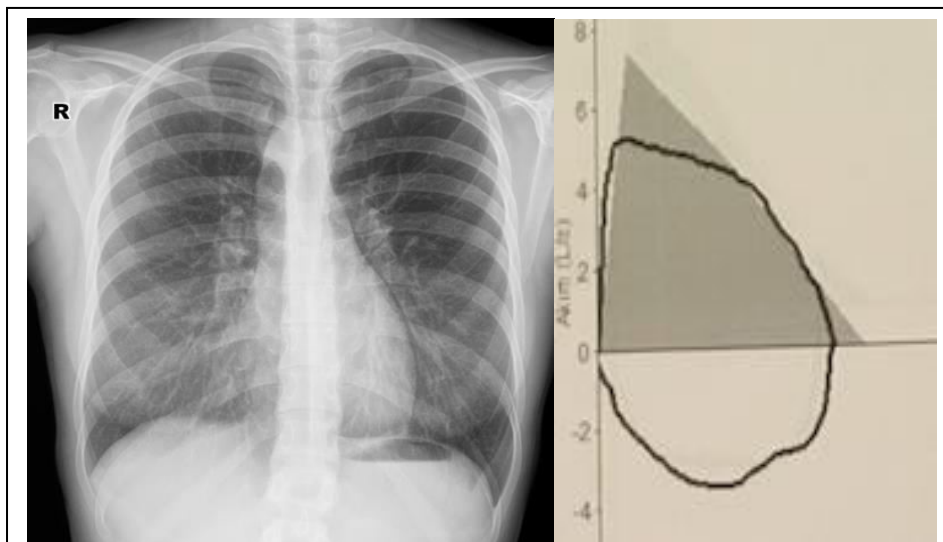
Chest radiography of 28years-old female showing the right sided arcus aorta and flow-volume curves showing the quadrilateralization pattern on spirometry.
